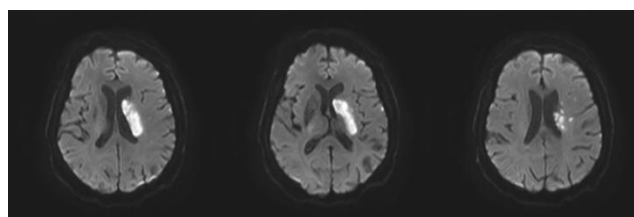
Brain MRI - presence of multiple lacunar ischemic lesions within the MCA territory.
